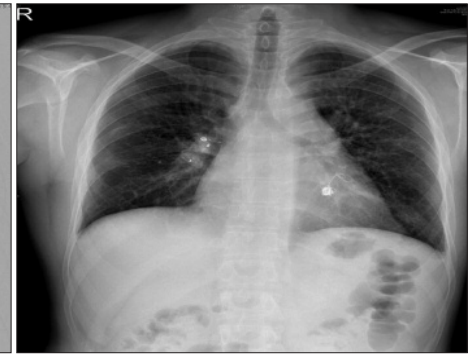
Chest Roentgenogram showing post-bilateral vascular plug and coiling, (vascular plug 2 (20 mm) right inferior branch of pulmonary artery with fibered coil in right upper and left lower lobe branches).
